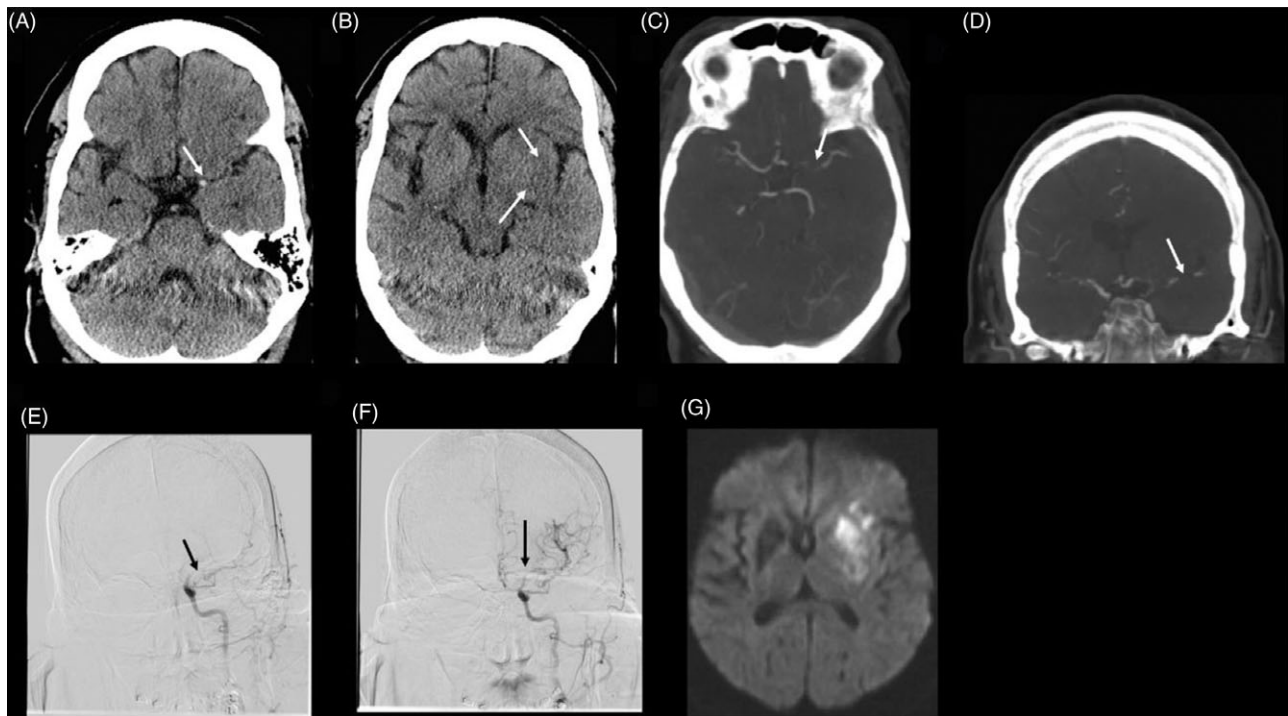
Diagnostic imaging and therapeutic intervention for the first case reported. (A) Axial CT head shows left MCA hyperdense sign indicating a fresh clot. (B) Axial CT head reveals early ischemic changes in the left insula and basal ganglia as indicated by the arrows. (C and D) Axial and coronal sections of CTA show thrombotic occlusion of the left carotid terminus extending into the left M1 segment of MCA. (E) Digital subtraction angiogram further demonstrates the same finding shown in CTA. (F) Digital subtraction angiogram shows revascularization after a successful endovascular thrombectomy. (G) Diffusion weighted imaging of the brain 24 h after the ischemic stroke reveals a diffusion restriction in the left insula and basal ganglia.
